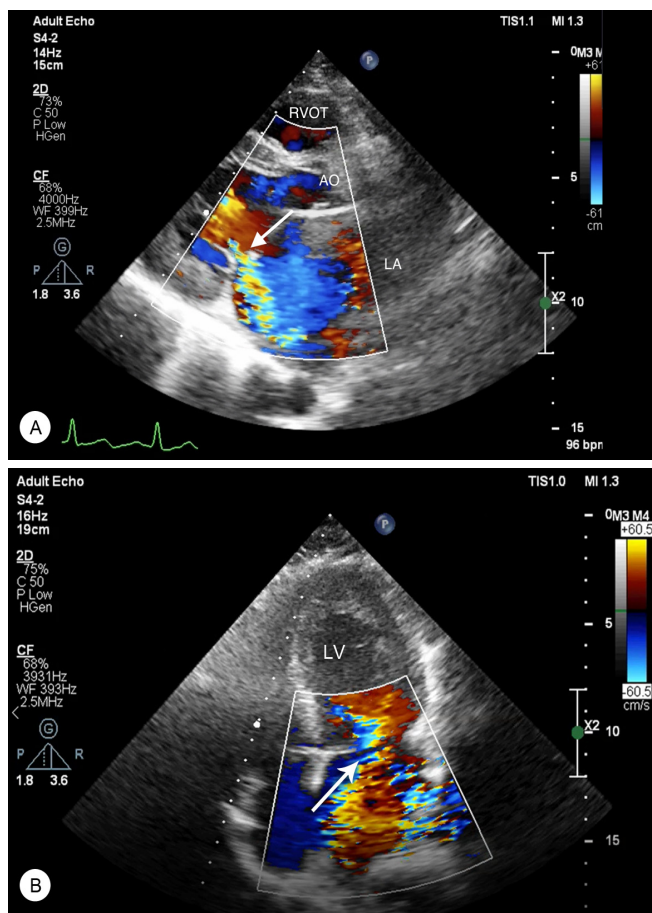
Continuous Doppler analysis of mitral regurgitation, Trans thoracic echocardiography four chamber view (A) and long axis view (B) showed flail of anterior leaflet of mitral valve with severe posterior lateral jet (Arrow)
